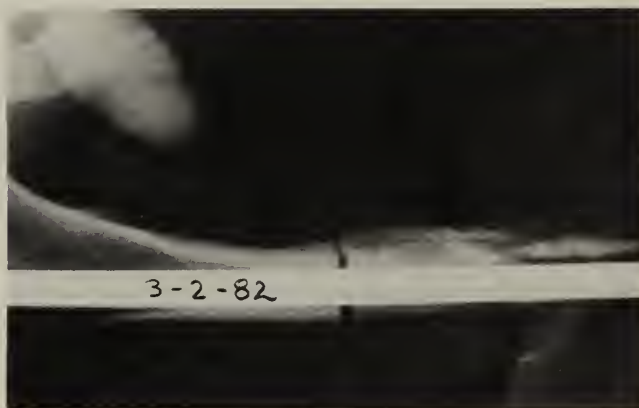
Roentgenogram of the femur immediately postoperative showing a new Kuntscher nail across the osteotomy site.
